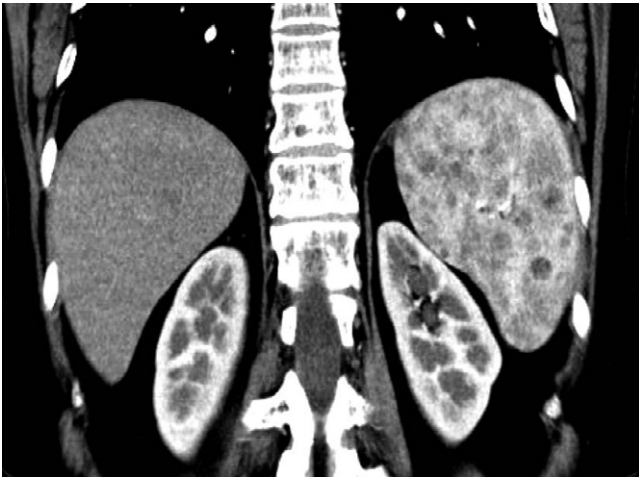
Coronal contrast-enhanced CT images at multiple well-defined, section showed with a diameter of about 2.0 cm.
